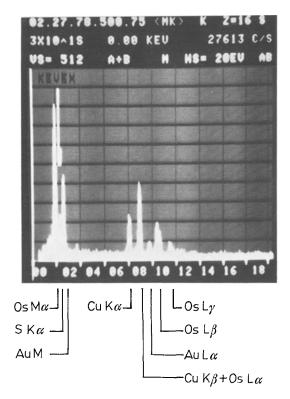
Display of characteristic X-ray images in a electron dense granule in the hepatocyte of a patient with PBC. White bars denote characteristic X-ray images of sulphur
